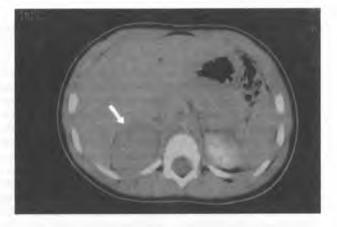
CT scan revealing a tumour of the right suprarenal gland
